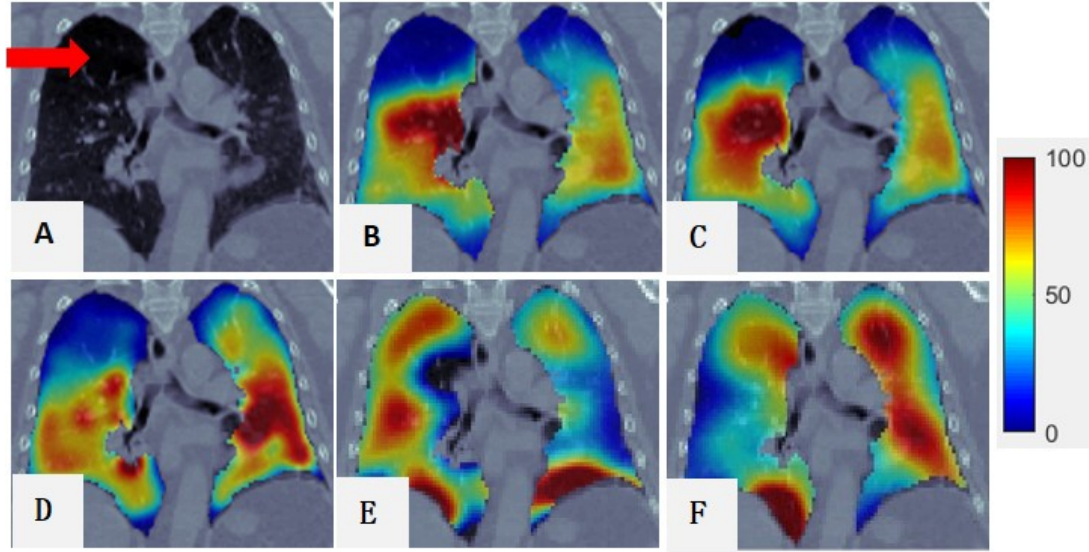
Comparison of RefVI image and CTVI_{SVD} images for a representative case without tumor blocking the airway. Figure (A) is CT; Figure (B) is the RefVI of the lung region superimposed onto the CT; Figure (C) is the V_{SV} of the lung region superimposed onto the CT; Figure (D) is the CTVI_{SVD} of the lung region superimposed onto the CT; Figure (E) is the CTVI_{Jac} of the lung region superimposed onto the CT; Figure (F) is the CTVI_{HU} of the lung region superimposed onto the CT. For all the figures, their 99th percentile and higher values were scaled to 100 (to reduce the artifact effect caused by the tracer deposited at airways in RefVI for visual inspection), and the minimum value was scaled to 0.
